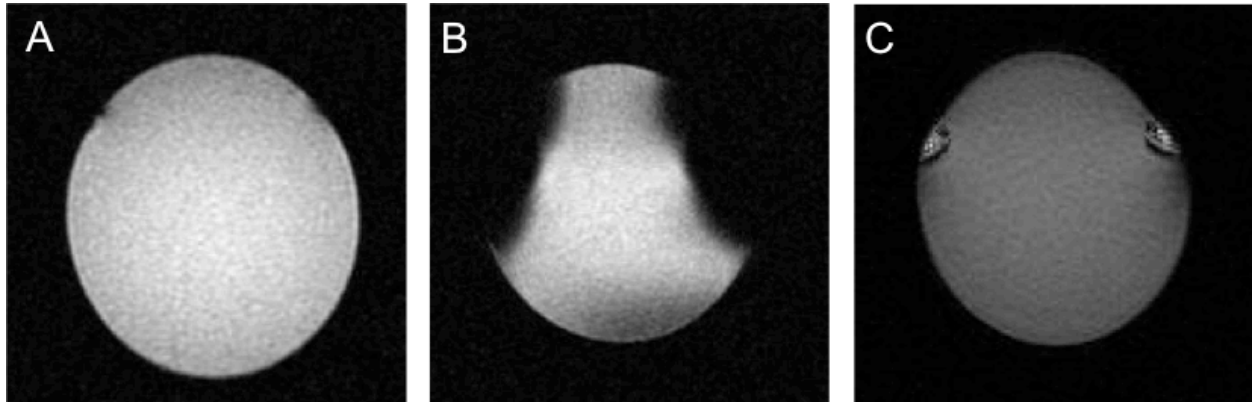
MRI Scans. A. Scan of sphinx design with 25 ms echo time. B. Scan of new design with 25 ms echo time. C. Scan on new design with 5.1 ms echo time. Photos courtesy of Wally Block.
